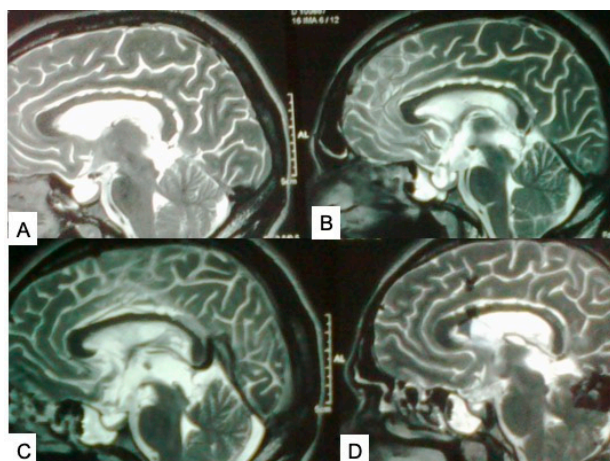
(A–D) MRI of the brain (T2W sagittal images) showing spontaneous CSF fistula through sphenoid sinus due to tuberculum sella and sella turcica defects. Source: Figure by authors.
